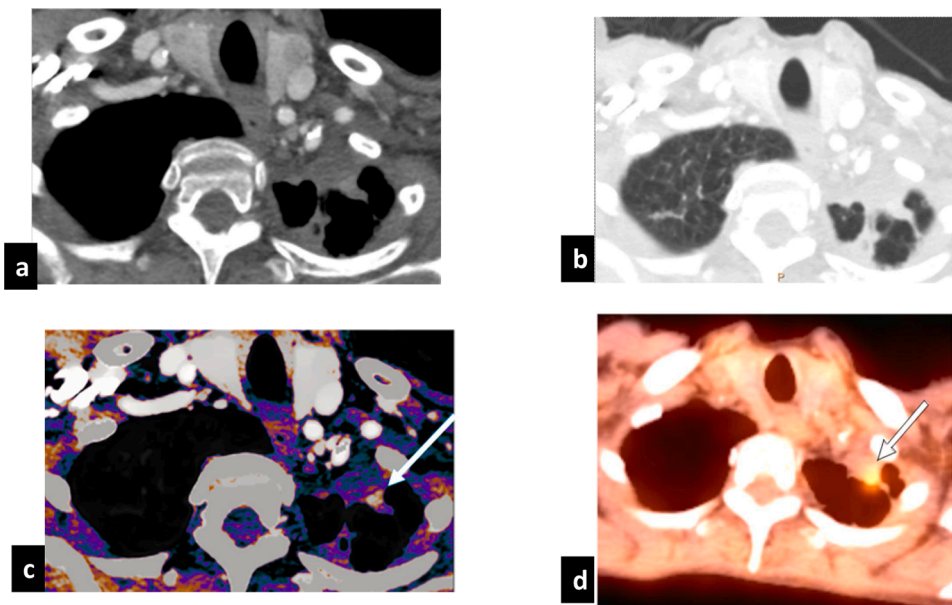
Improved lesion detection with DECT. A 79-year-old female with history of left upper lobe adenocarcinoma status post resection and radiation therapy returning for restaging scan. On conventional CT images in soft tissue and lung window settings (a, b), there is left apical post-surgical scarring seen without definite local recurrence. However, on iodine overlay image (c) there is focus of increased iodine accumulation within the scarring (Blue arrow), which correspond to increased radiotracer uptake on subsequent PET-CT fusion image (Red arrow in d). Pathology confirmed recurrent adenocarcinoma.
